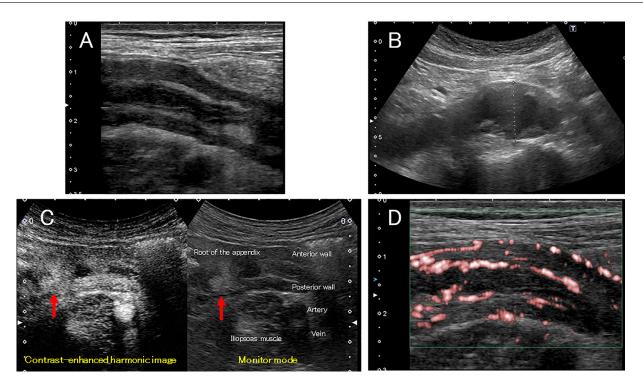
Transabdominal ultrasonography findings. Transabdominal ultrasonography findings included a diffuse thickening of the entire appendix wall (A) and an anechoic area with the appearance of fluid collection in the appendix lumen (B). Contrast-enhanced ultrasonography revealed a contrast effect at the root of the appendix (C, red arrows). Contrast-enhanced ultrasonography combined with superb microvascular imaging revealed an abundant mucosal blood flow and no abnormal vascular network within the mucosa of the appendix wall (D).
